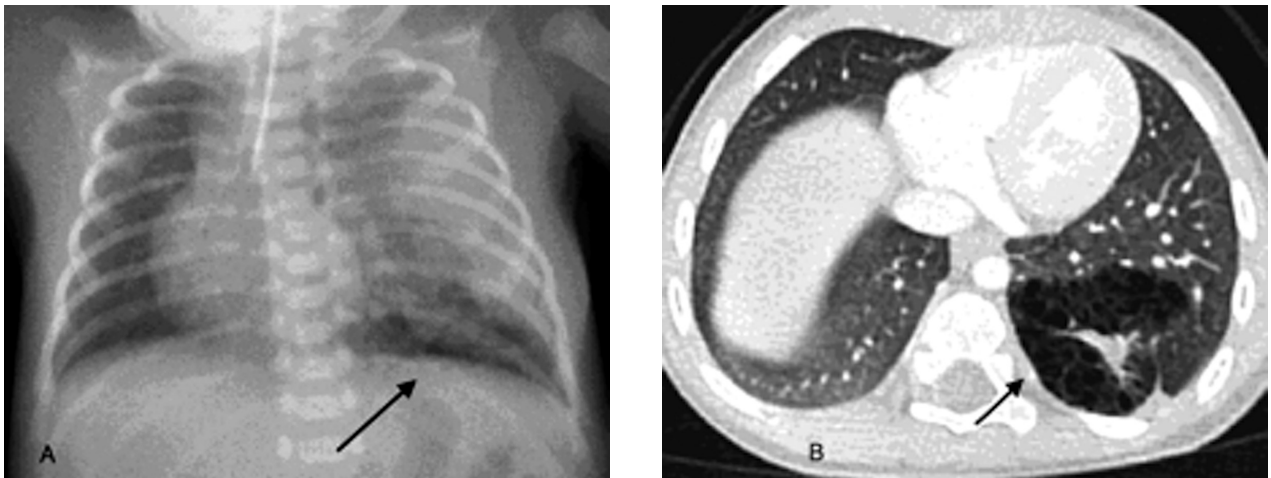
(A) XR shows accentuated left basal retrocardiac bronchovascular markings. (B) CT detects a malformation characterized by multiple parenchymal cysts with thin walls and thickened band of dysplastic parenchyma
